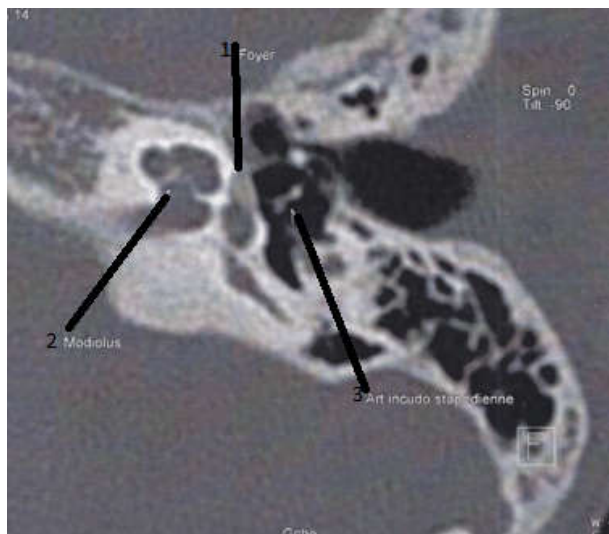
Axial CT scan showing the otosclerosis focus at the fissula ante fenestram associated with posterior involvement of the The footplate of the stapes 1. Otosclerosis focus 2. Modiolus or columella 3. Incudo-stapedial joint
